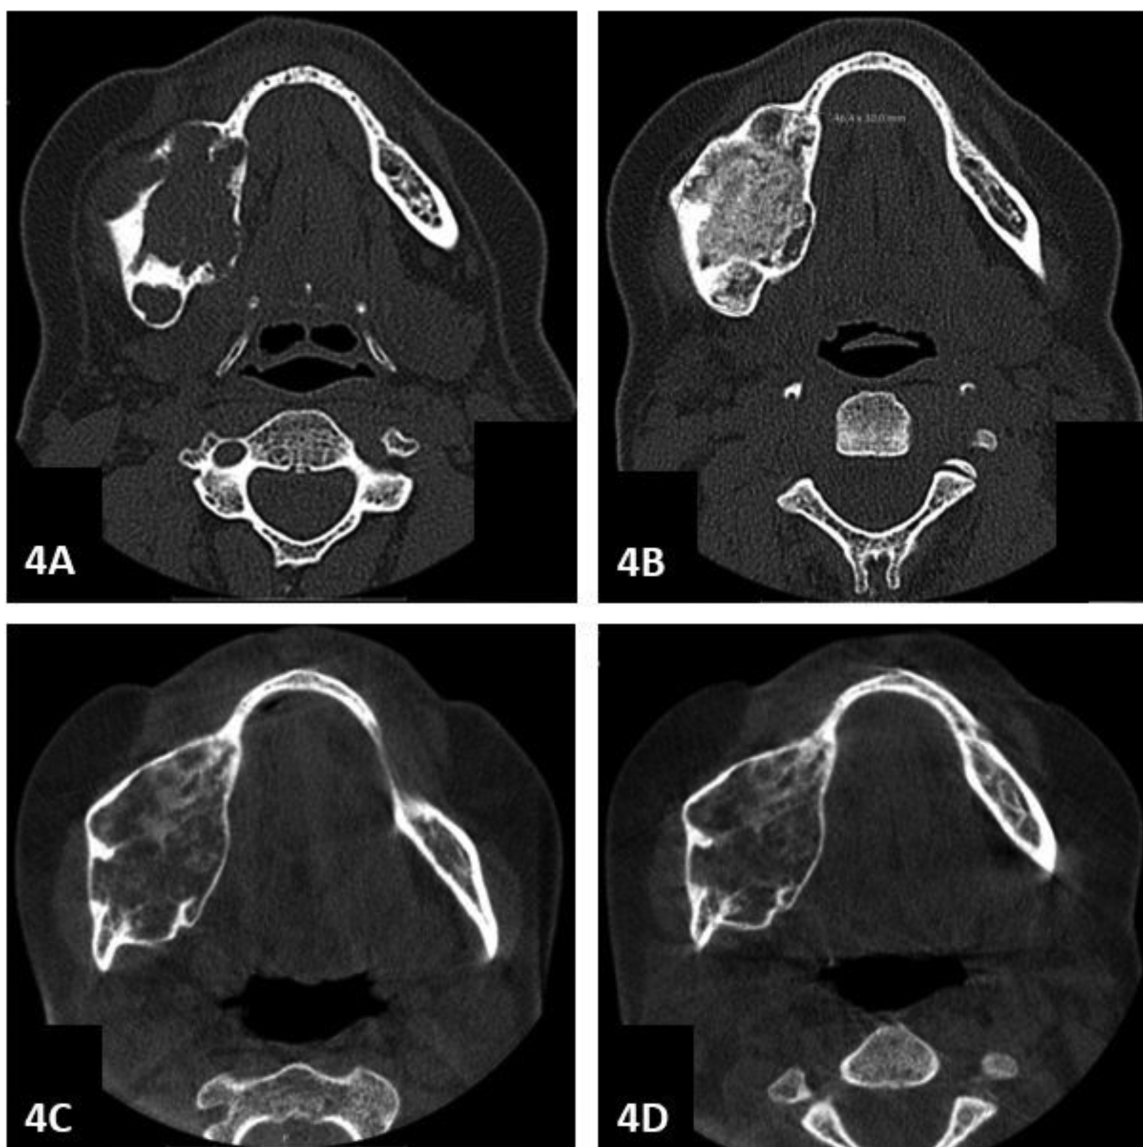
CT images patient 4 (treated outside of study). (4A) baseline CT; central giant cell granuloma (CGCG) body of the right mandible, (4B) after 6 cycles; ossification of the affected right hemimandible, (4C) 5 years after discontinuation of denosumab; decreased ossification and lytic process right mandible, indicating recurrence of CGCG, (4D) after one year of treatment, stable lesion, no increase in ossification.
